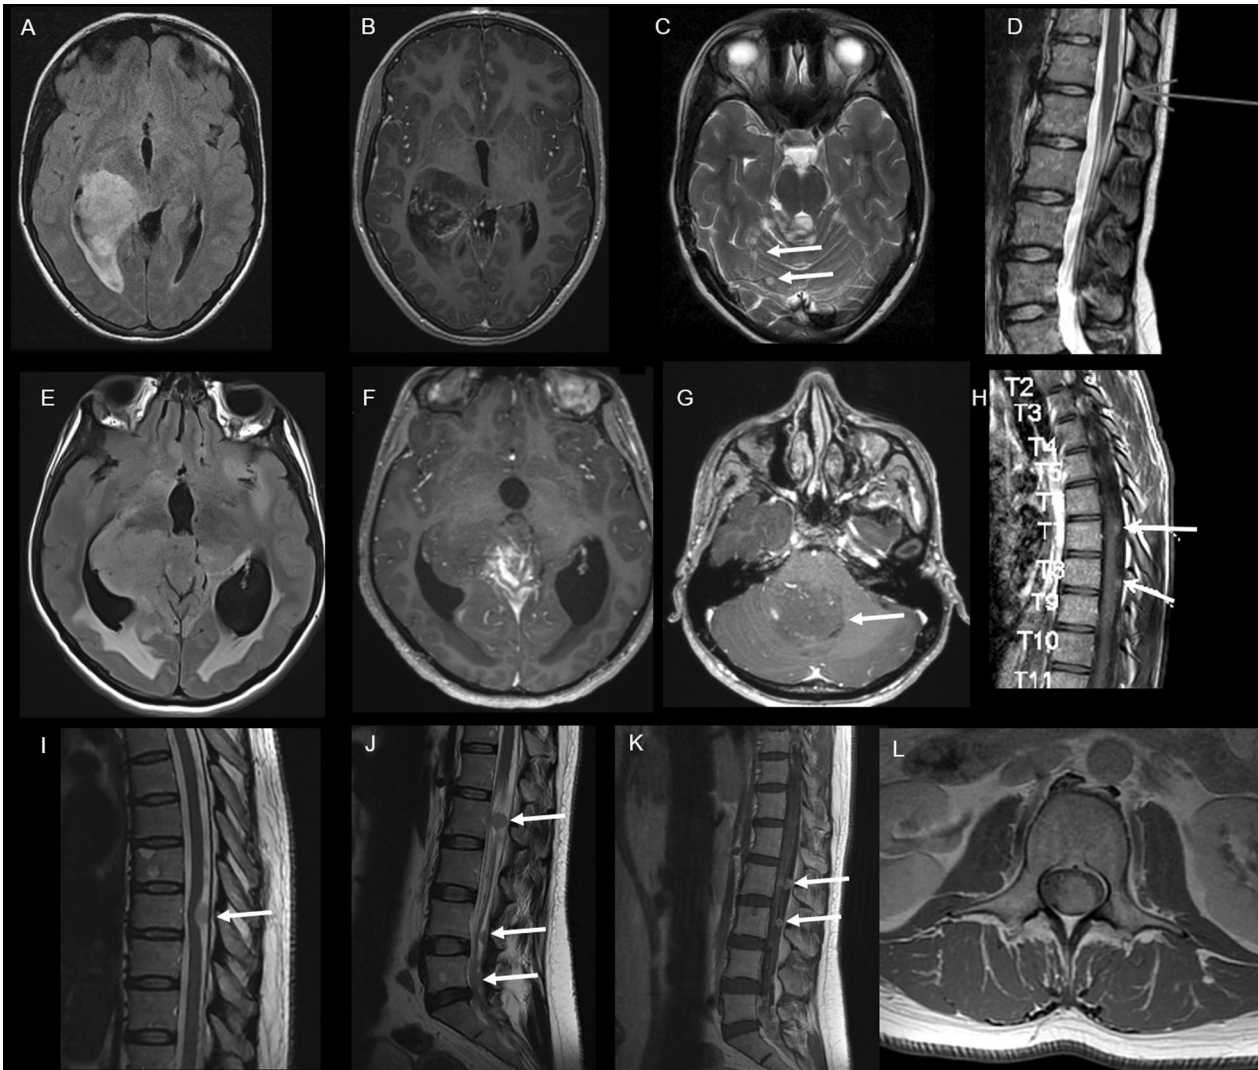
Radiological features. Case #1 A Axial FLAIR brain MRI shows a hyperintense infiltrative lesion of the right thalamus extended to the right lateral ventricle. B Axial contrast-enhanced T1-weighted brain MRI shows a heterogeneous enhancement after gadolinium injection. C Axial T2-weighted brain MRI shows other nodular FLAIR hyperintensities of the cerebellum (arrows). D Sagittal T2-weighted spine MRI shows a hyperintense peripheral lesion of the spinal cord (arrow). Case #2 E Axial FLAIR-weighted brain MRI shows a hyperintense lesion of the right thalamus extended to the third ventricle and the right hippocampus. F Axial contrast-enhanced T1-weighted brain MRI shows a heterogeneous enhancement of this lesion. G Axial contrast-enhanced T1-weighted brain MRI shows an intraventricular localization in the fourth ventricle (arrow). H Sagittal contrast-enhanced T1-weighted spine MRI shows multiple spinal leptomeningeal lesions. Case #3 I Sagittal T2-weighted spine MRI shows a thoracic hyperintense leptomeningeal lesion. J Sagittal T2-weighted lumbar MRI shows multiple lumbar intradural lesions, attached to nerve roots and in the lower end of the dural sac. K Sagittal and L Axial contrast-enhanced T1-weighted lumbar MRI show an enhancement of these lesions. FLAIR: Fluid Attenuated Inversion Recovery
